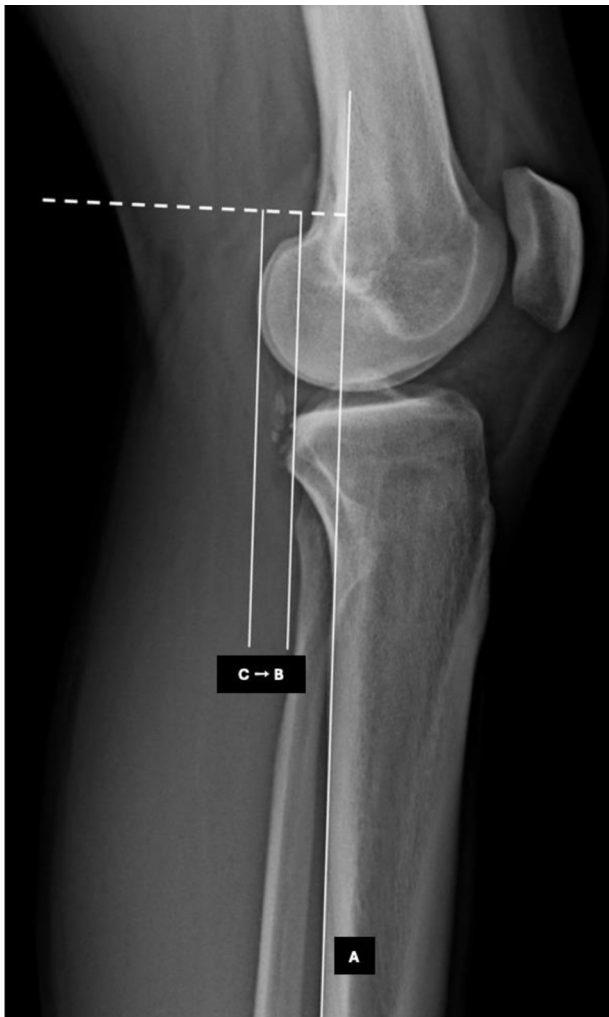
Lateral knee radiograph showing the measurement of static anterior tibial translation (SATT). The posterior cortical bone of the tibia is used as a reference (A line). Two lines are drawn parallel to line A and tangent to the posterior aspect of the medial tibial plateau (line B) and to the femoral condyles (line C). SATT corresponds to the distance between lines B and C.
